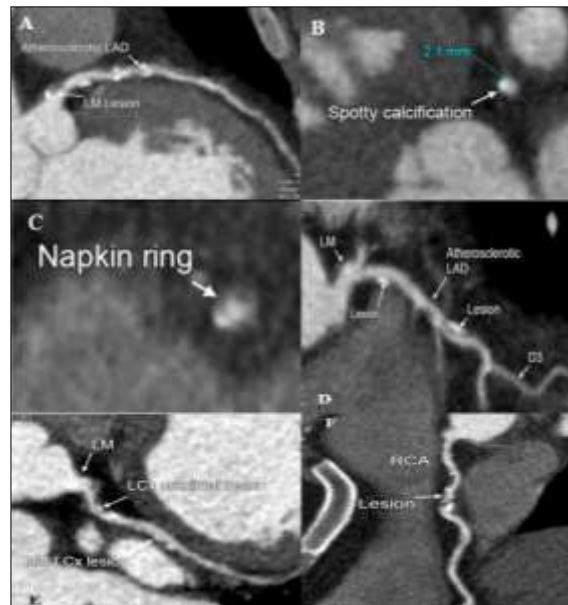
Coronary CT angiography reveals a short patent atherosclerotic left main artery with a mixed eccentric susceptible plaque at its distal segment, causing mild stenosis of about 50% across a length of about 4 mm. The cross-sectional images of LM lesions reveal vulnerable plaque characteristics, such as spotty calcification and the napkin ring sign. In image (D), a curved MPR image shows multiple mixed eccentric and concentric plaques in the proximal and mid-segments of the LAD, with positive remodeling. The largest plaque causes severe stenosis of approximately 70% in the mid-segment. In image (E), a curved MPR image shows a positively remodeled mixed eccentric plaque in the proximal segment of the LCx, causing moderate stenosis of about 60% over a length of 8 mm. Another mixed eccentric plaque is observed in the mid-segment of the LCx, causing mild stenosis of about 40% over a length of 9 mm. In image (F), a curved MPR image reveals multiple calcified and mixed eccentric plaques in the proximal and mid-segments of the RCA, resulting in moderate stenosis of about 50% in the proximal segment and severe stenosis of about 90% in the mid-segment.
